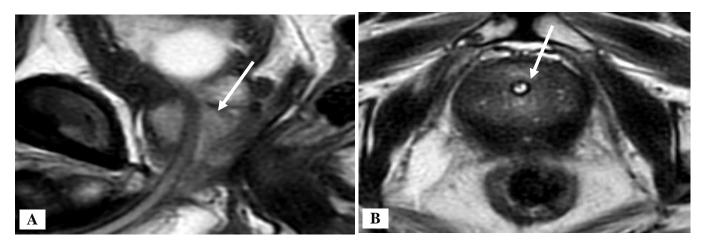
Sagittal and axial MRI T2 weighted images post-radiotherapy of a case of metastatic castrate resistant prostate cancer.
